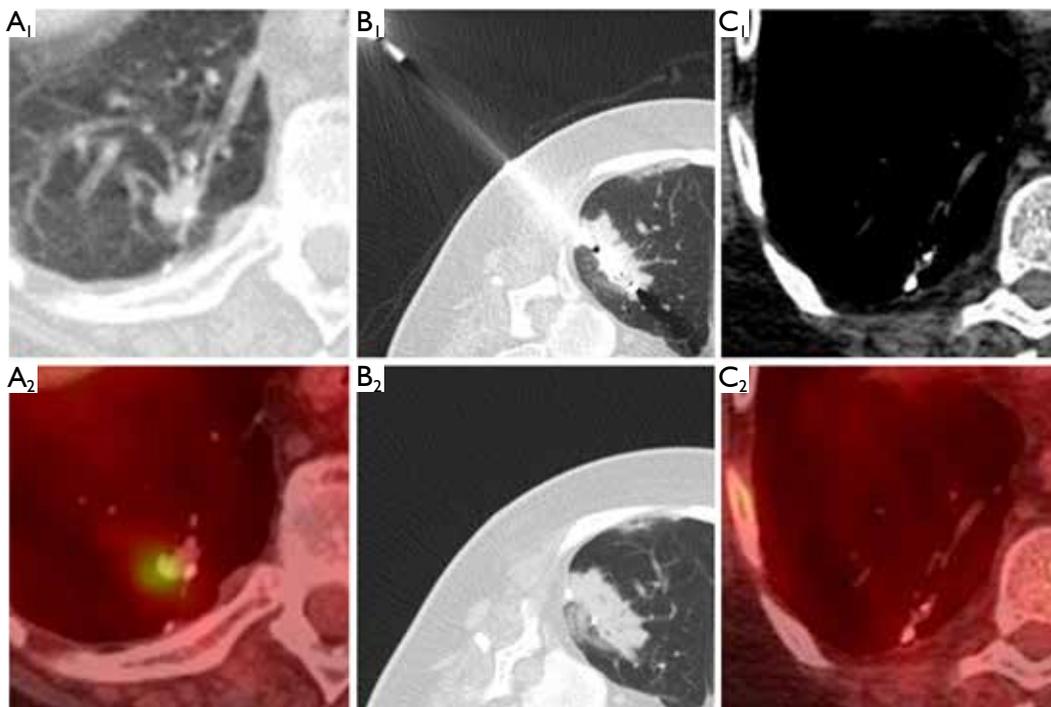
Right lower lobe nodule previously treated with surgery. (A₁) Axial CT image shows a small nodule next to a surgical staple line; (A₂) Correlating PET/CT image shows focal nodular hypermetabolic activity within the nodule, consistent with local tumor recurrence; (B₁) Axial CT image shows a cryoablation probe within this right lower lobe lesion; (B₂) Immediate post-cryoablation image shows expected groundglass opacity surrounding the lesion; (C₁) CT at 1-year follow-up shows resolution of previous nodule by staple line; (C₂) Correlating PET/CT image at 1-year follow-up shows no FDG uptake by staple line
